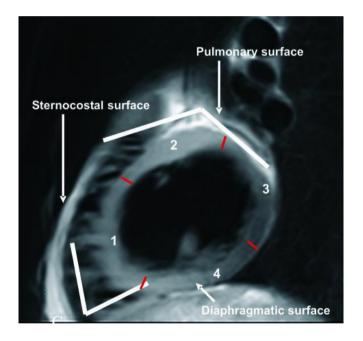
(c): Cardiac radiograph in short axis view of a section of left ventricle showing acute angle between sternocostal and diaphragmatic surfaces and obtuse angle between sternocostal and pulmonary surfaces. Red lines show the division of the left ventricle into segments (Anderson, Razavi, and Taylor, 2004).
